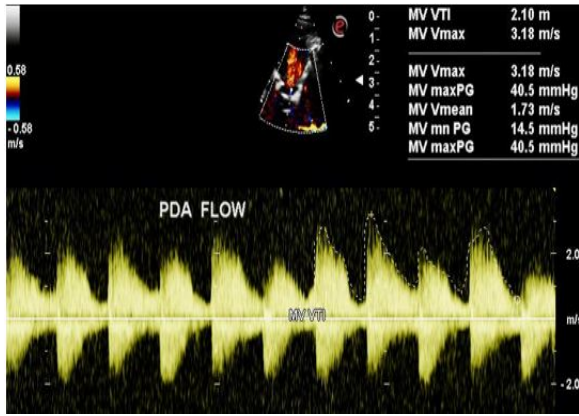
On CW Doppler analysis across PDA peak/mean gradient was 40.5/ 14.5 MMHg
